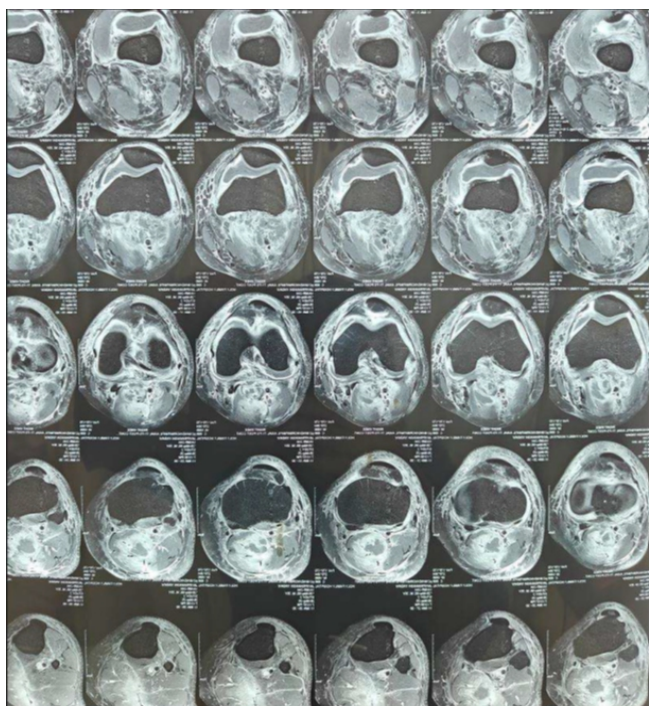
Magnetic resonance imaging axial T2-weighted image showing diffuse hyperintensity in the vastus lateralis, vastus medialis, and medial gastrocnemius muscles consistent with pyomyositis.
